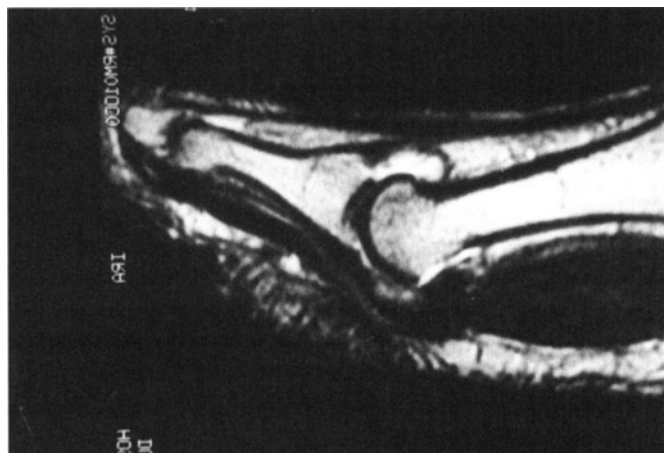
Sagittal T1-weighted MR image showing tenosynovitis. Note enlarged FHL tendon distal to sesamoids and fluid in tendon sheath.
